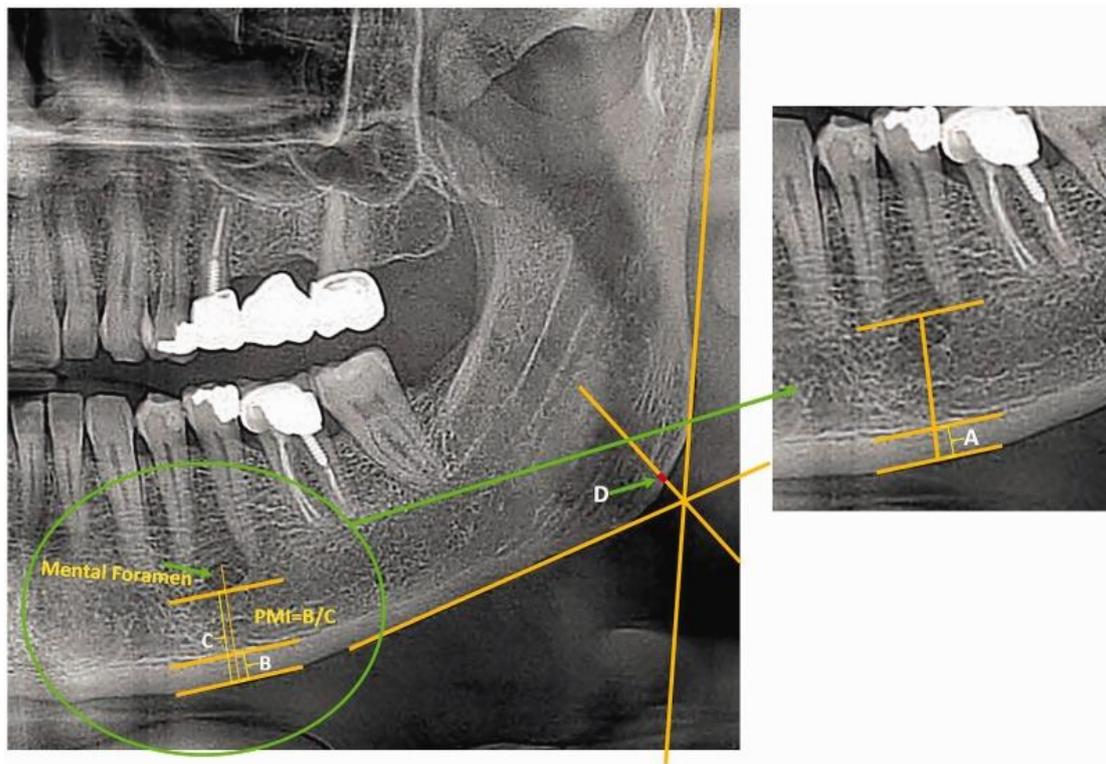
MI width (width A) as measured on an orthopantomogram. Orthopantomogram used to calculate PMI ($PMI = B/C$). Orthopantomogram showing AGI measurement (width D). AGI stands for antegonial index; PMI stands for panoramic mandibular index. (Sghaireen MG,2020)
